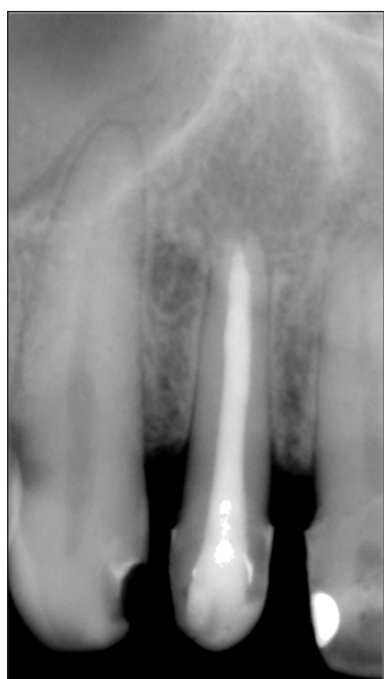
Radiograph taken after three years, which shows complete resolution of the lesion.
